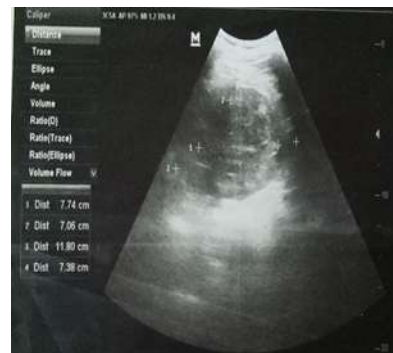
The ultrasonogram of left kidney showing isoechoic mass filling the medullary area
